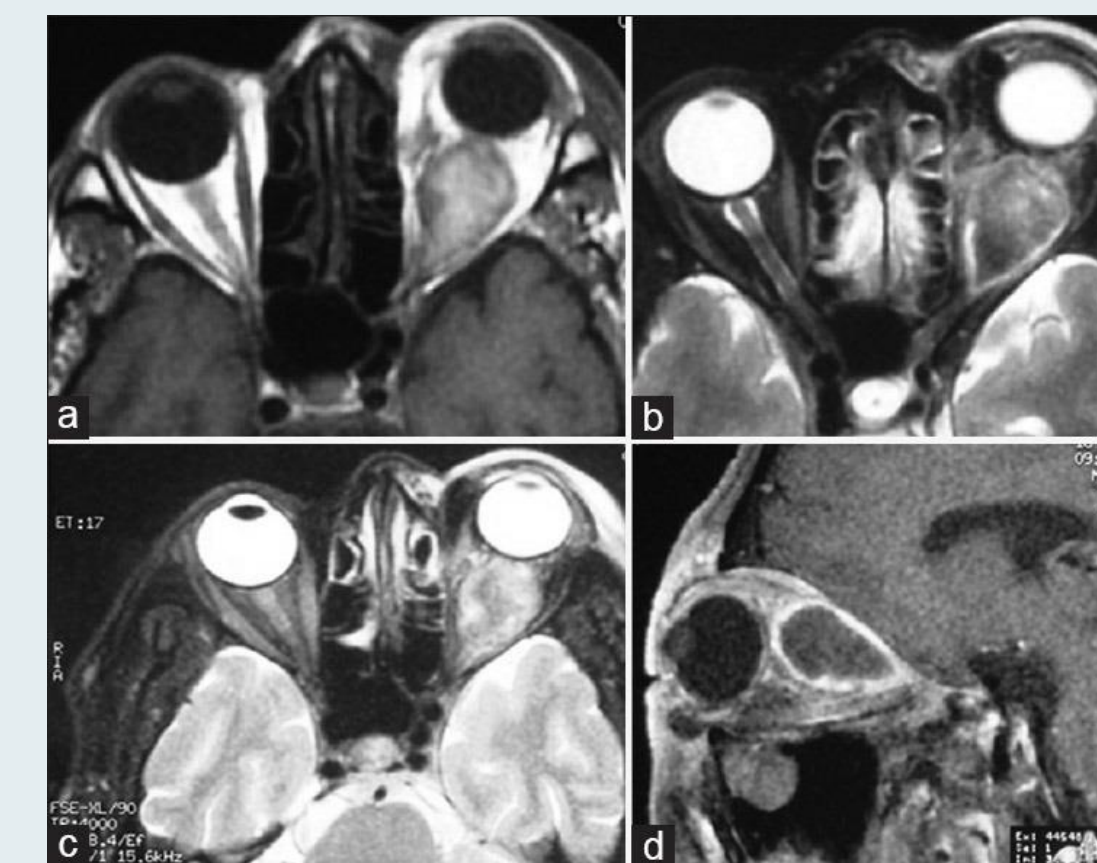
Orbital MRI showed an intraconal mass that was heterogeneous to hyperintense on T1 images (a) and heterogeneous to hyperintense on T2 images (b and c) with gadolinium enhancement at the rim of the lesion on T1 images (d). In some sections, the mass seems to be hyperintense on T1 images (a) and in some others, hypointense (d). The same finding can be seen on T2 images (b and c)
